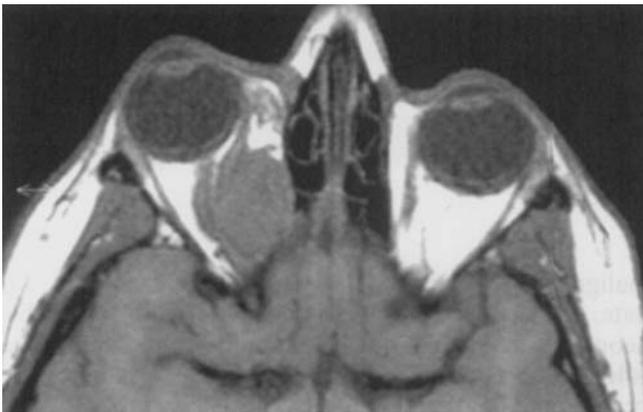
Cranial magnetic resonance. In a T1-weighted scan an ovoid, hypointense mass (largest diameter: 2.5 cm) is visible inside the right orbit, not clearly dissociated from the medial rectus muscle and displacing the optic nerve towards the right
